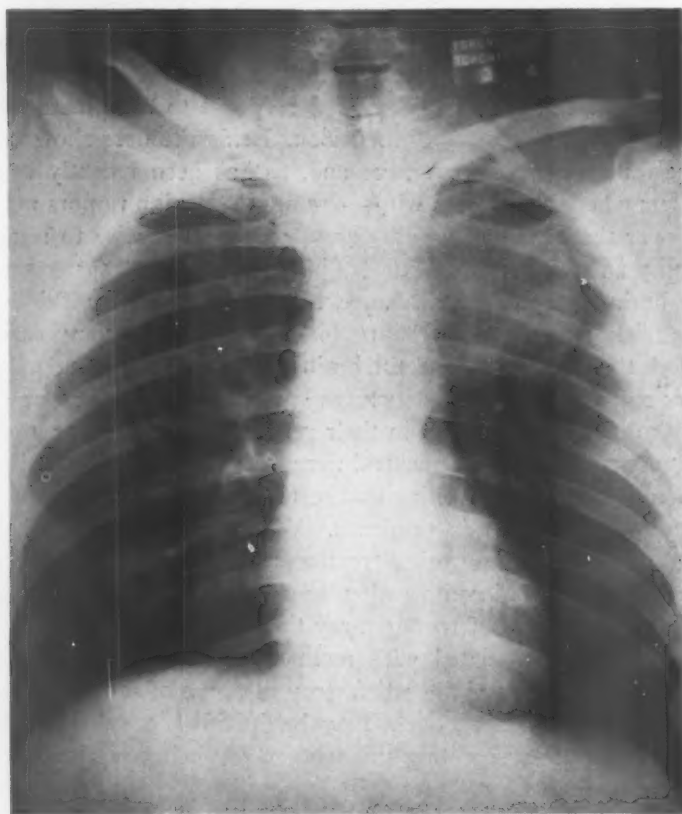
Roentgenogram of chest showing large rounded mass in left upper thoracic cavity.
